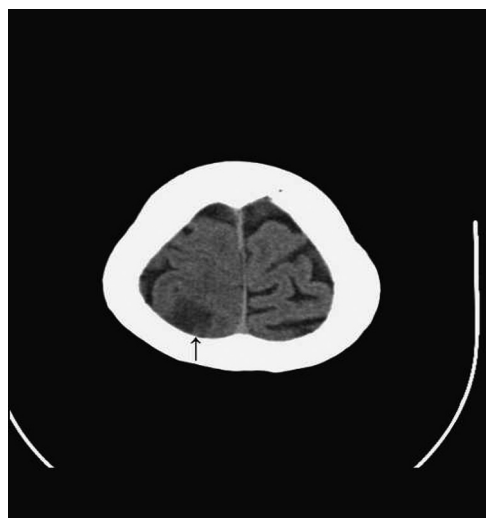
Axial noncontrast brain computed tomography (CT) showing a low density lesion of unknown nature detected in the right high parietal region (arrow).
